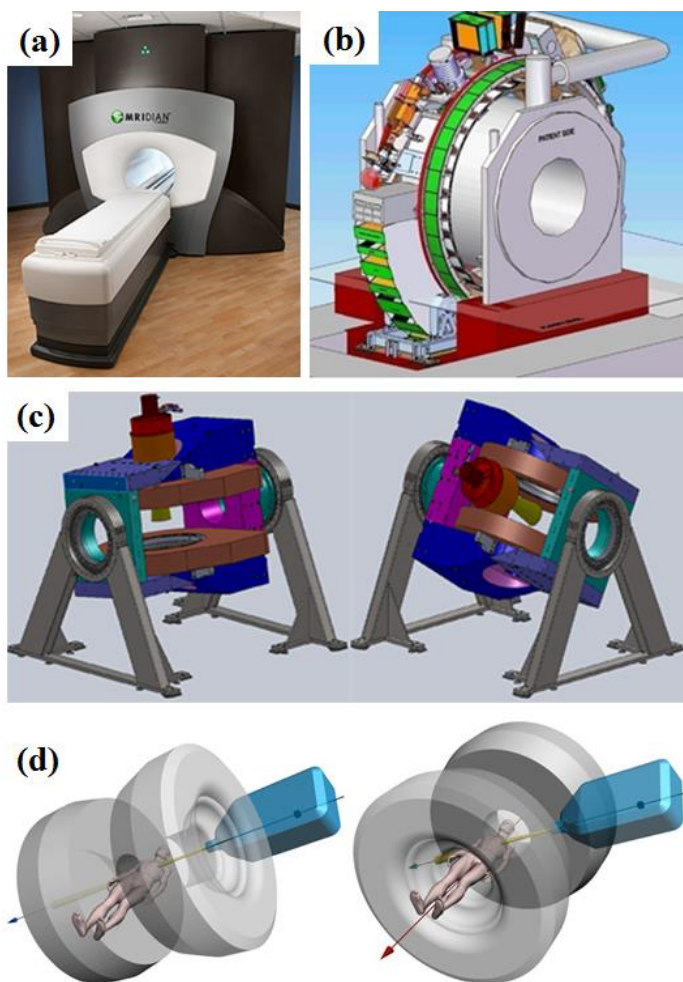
MRI combined with radiation therapy systems. (a) ViewRay System (US), (b) Utrecht (The Netherlands), (c) Alberta (Canada) and (d) Australian MRI-Linac (Australia).
